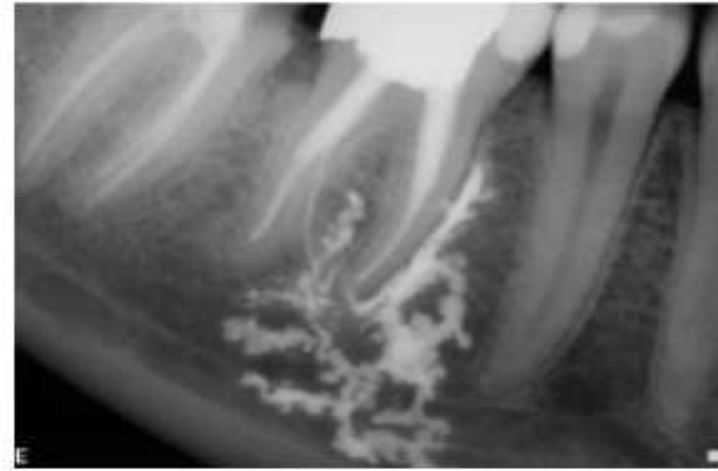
Large zinc-oxide-eugenol sealer overfill was tolerated by the patient for many years and remains asymptomatic today. There was no neurovascular involvement. Radiograph courtesy Dr. Roxanne Benison.
